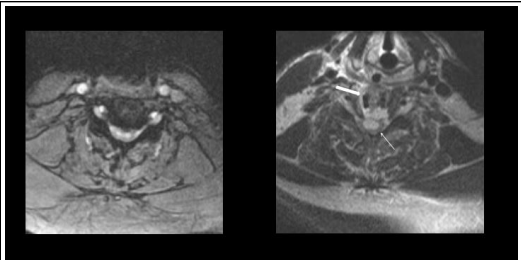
T2 axial MRI of cervical spine showing cervical stenosis with myelomalacia (left). Intraoperative MRI (right) shows decompressed canal with allograft bone (large arrow) and increased myelomalacia (small arrow).
